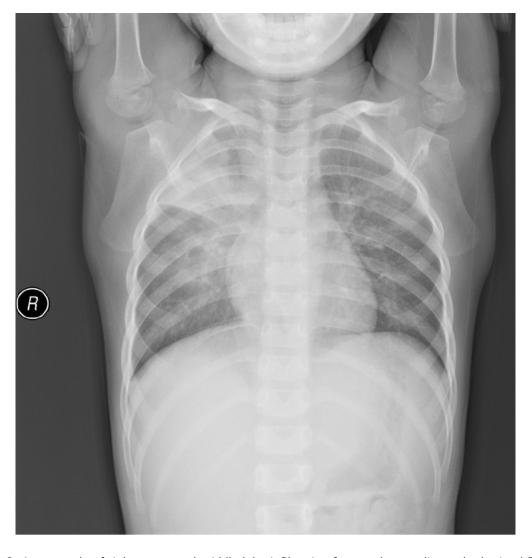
An example of right upper and middle lobe infiltration from a chest radiograph obtained 5 days after the onset of symptoms in a 2-year-old girl with mycoplasma pneumonia. $87x91mm (300 \times 300 DPI)$
